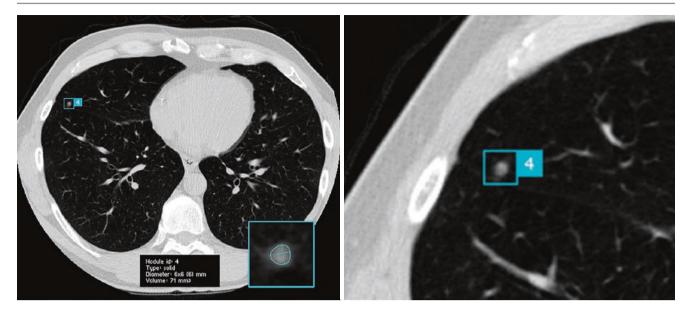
Bounding box around a lung nodule on chest CT, with a magnified view on the right [29]
